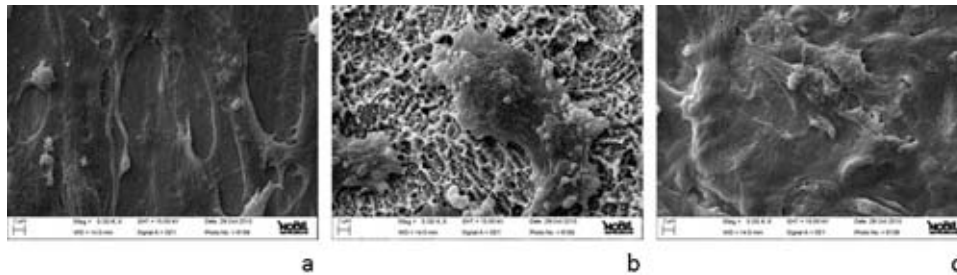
Representative SEM images (5000 $\times$ ) of SaOS2 cells after 5 days culturing on P, SA and SUV samples.
